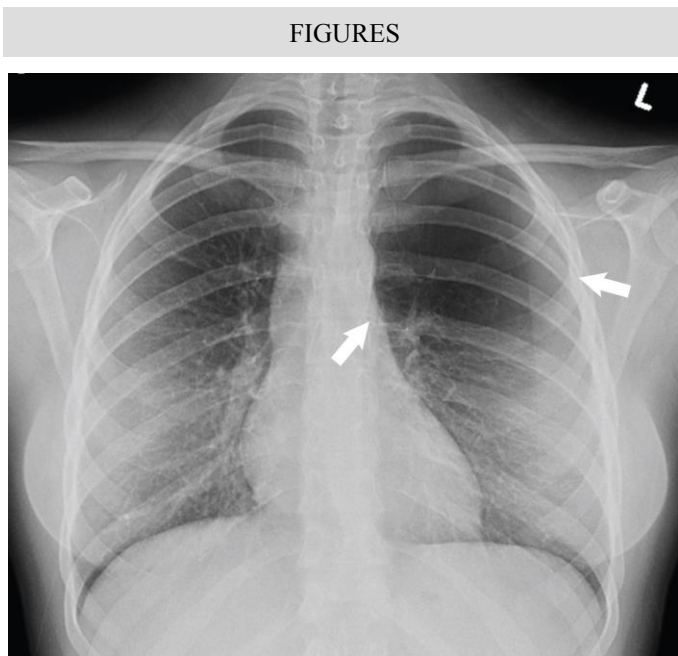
Anterior-poster chest X-ray of the 20-year old female patient with congenital lobar emphysema presented in this case. The emphysematous left upper lobe (LUL) is indicated with white arrows. The LUL has markedly reduced lung density and hyperinflation which has caused the mediastinum to shift onto the contralateral right lung.
